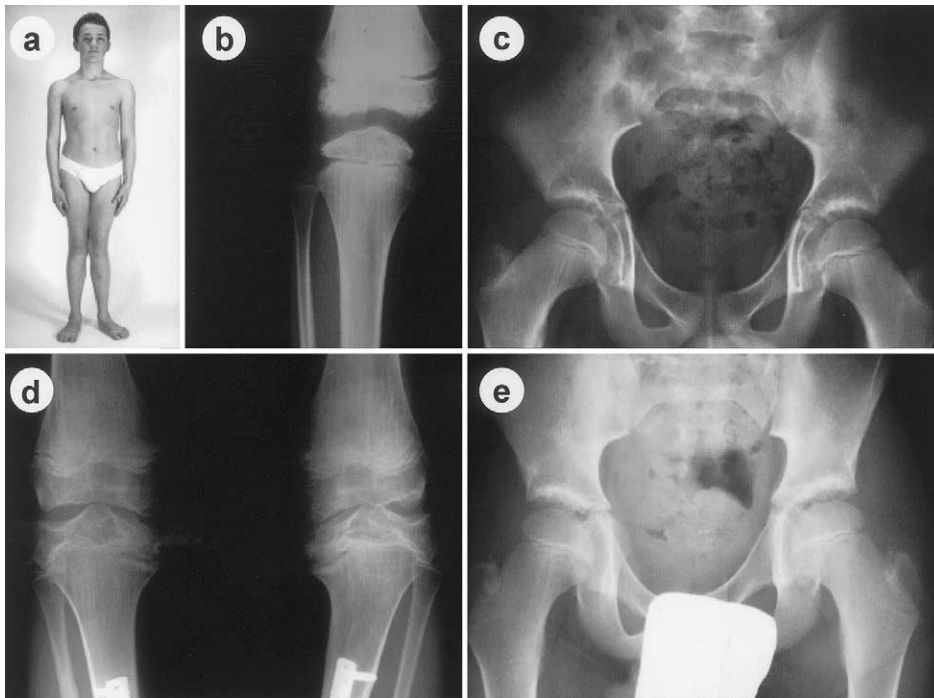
Radiographic findings in individual JK and affected individuals from family G. *a*, Individual JK at age 15 years. *b*, Individual JK at age 9 years 9 mo. Note flattened and irregular epiphyses. *c*, Individual JK at age 11 years 5 mo. *d*, Individual IV-2 (family G) at age 14 years 6 mo. Note flattened irregular epiphyses and metal plates from the tibial osteotomy that was performed at age 13 years. *e*, Individual IV-1 (family G) at age 10 years.
